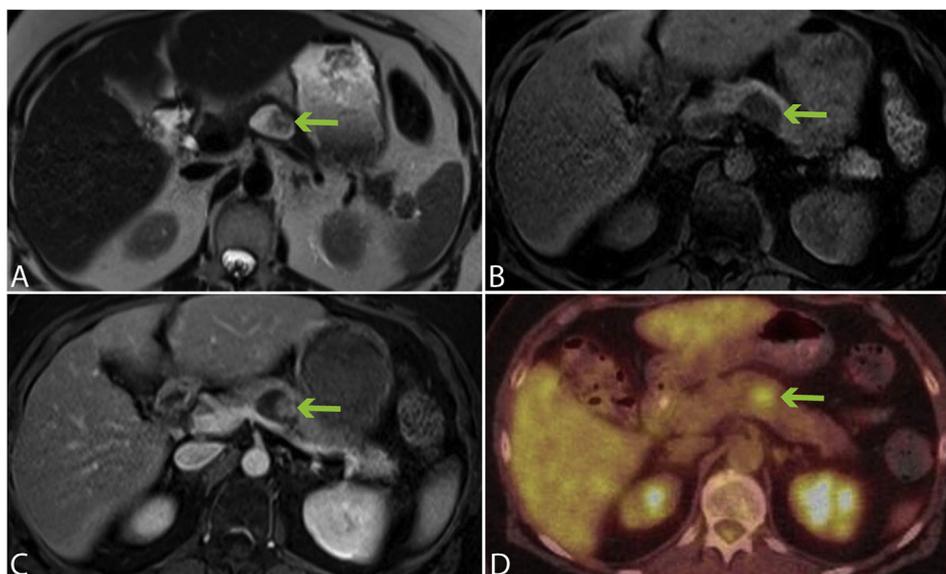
Imaging findings of a pancreatic schwannoma in a 64-year old woman. A: T2-weighted fast spin-echo image shows a heterogeneous mass with both high and low signal intensity (arrow) components. B–C: Axial fat suppressed T1-weighted images obtained before and after gadolinium administration show that the T2 hypointense components show enhancement (arrow). D: Corresponding FDG-PET image shows increased activity in the lateral aspect of the lesion (arrow) corresponding to the enhancing solid components shown in figure C. FDG-PET: Fluoro-deoxyglucose positron emission tomography.
